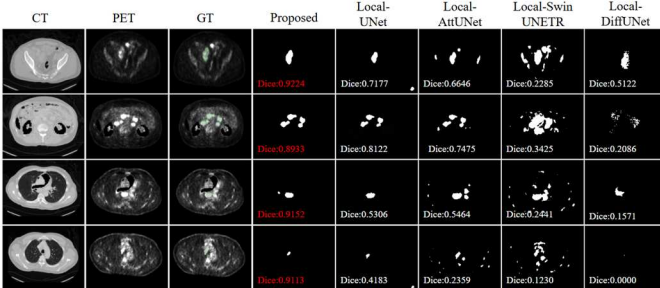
Qualitative comparison of different methods during the local segmentation phase for PET/CT lymphoma segmentation tasks. Using the axial view as an example, from top to bottom: AutoPET_20_block00, AutoPET_20_block01, AutoPET_20_block02, AutoPET_20_block03.
